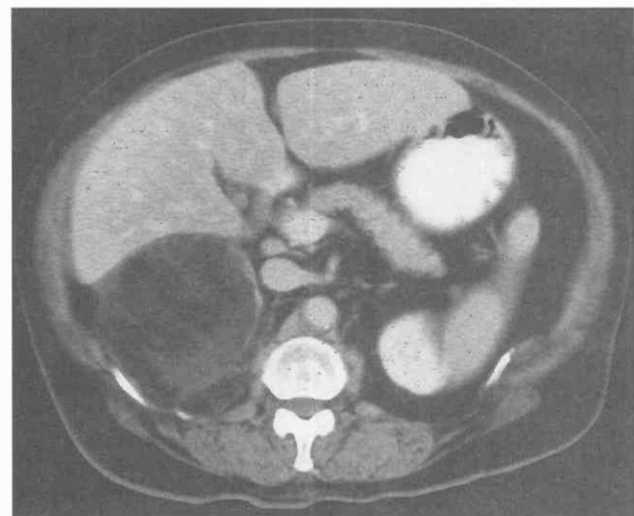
Myelolipoma. Contrast-enhanced CT scan of the abdomen reveals a 6-cm by 7-cm right adrenal mass containing both fat and soft tissue elements. This appearance is compatible with a myelolipoma.
